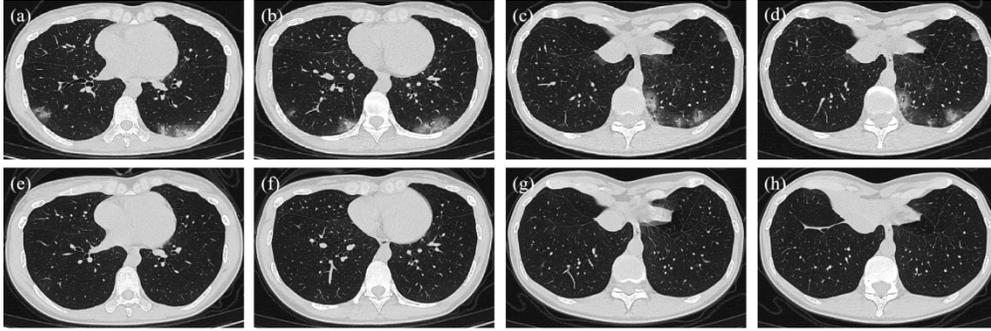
The chest CT scans from a 34-year-old female COVID-19 patient. (a~d) the chest CTs at admission; (e~h) the chest CTs four weeks after the discharge showed that multiple patchy GGO in the lower lobes, consolidations and bronchiectasis mostly got recovered.
